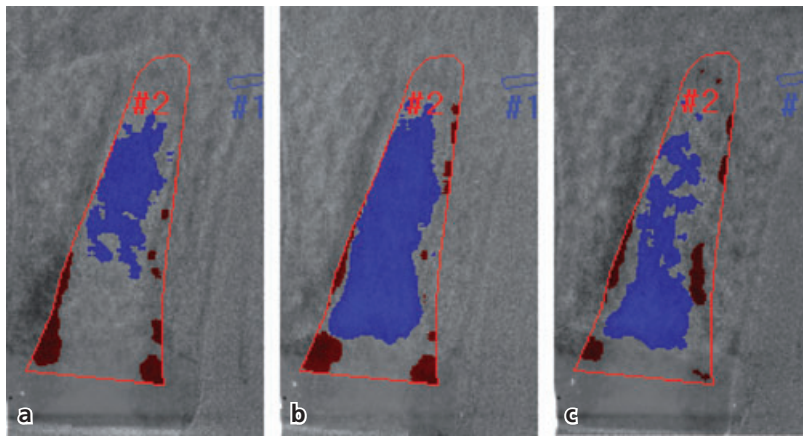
Radiographic (subtraction radiography) images of an extraction site obtained after (a) 3 months, (b) 6 months, and (c) 12 months of healing. The blue color represents areas of new bone formation. During the first 6 months, the deposition of new bone was intense. Between 6 and 12 months, some of the newly formed bone was remodeled. (Courtesy of Dr. L. Schropp.)
